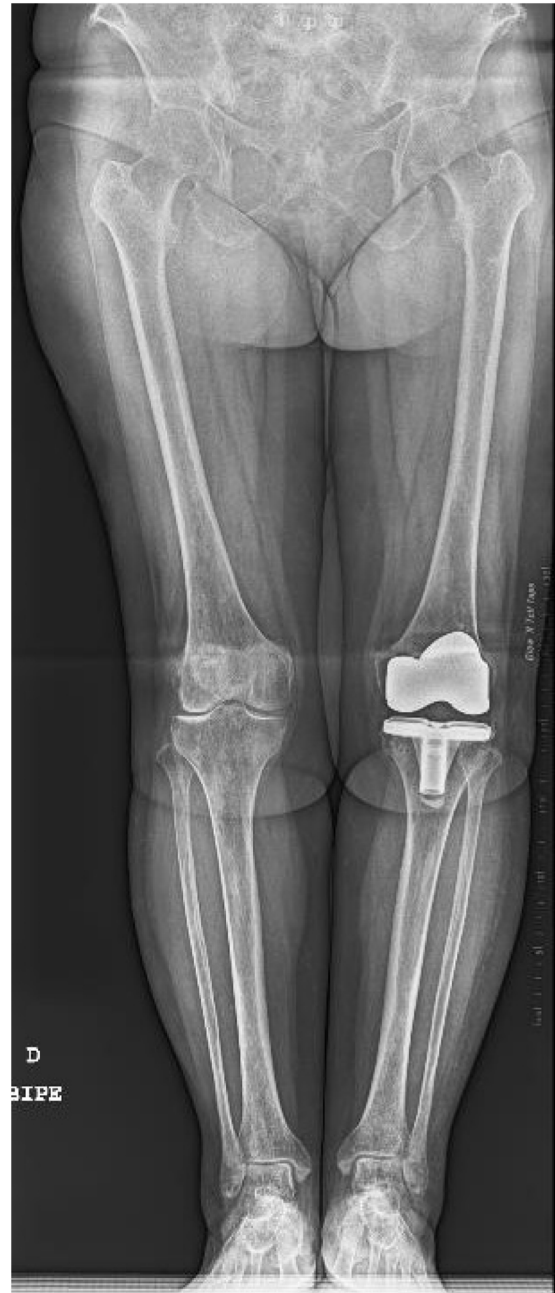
Postoperative X-ray image.
